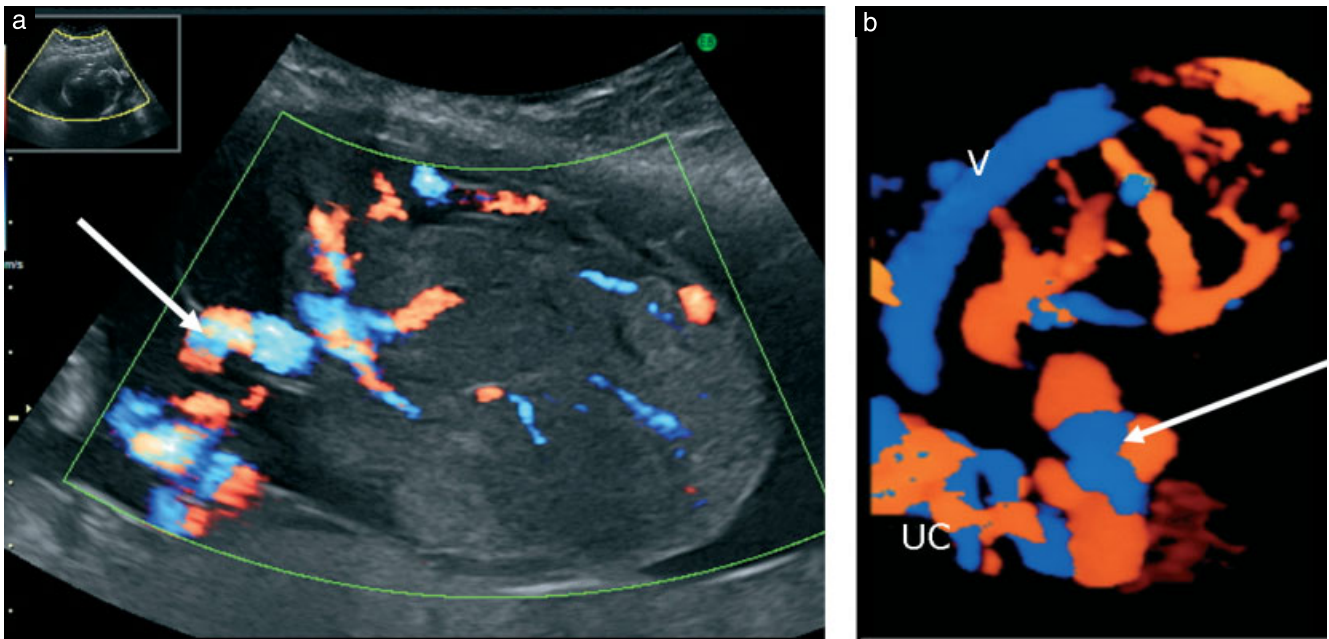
(a) Doppler ultrasound image of the chorioangioma before embolization showing hypervascularization and two feeding vessels (arrow), one of which had arterial pulsatility at the same rate as the fetal heart; the other had a venous spectrum. The mass was surrounded by a thin membrane. (b) Three-dimensional color Doppler image of the mass showing the origin of the feeding vessels (arrow) of the chorioangioma close to the placental umbilical cord insertion (UC). A large vein (V) ran superficially around the mass.
